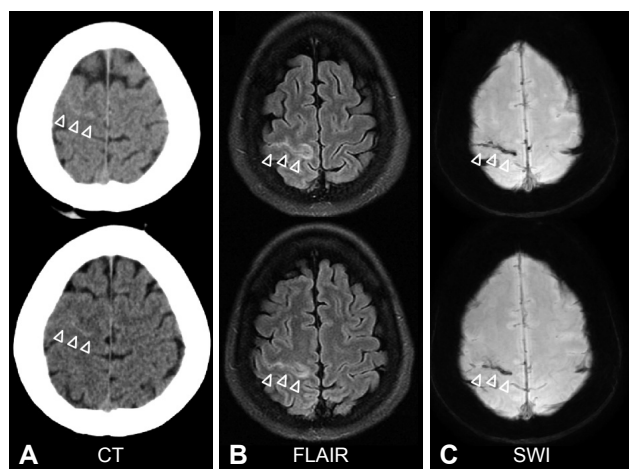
CT and MRI of the patient. A: Brain CT revealed a thin hyperdense line along the right central sulcus. B: Fluid-attenuated inversion recovery (FLAIR) images show hyperintensity along the right central sulcal space. C: Susceptibility-weighted imaging (SWI) revealed hypointensity in the right central sulcus.
